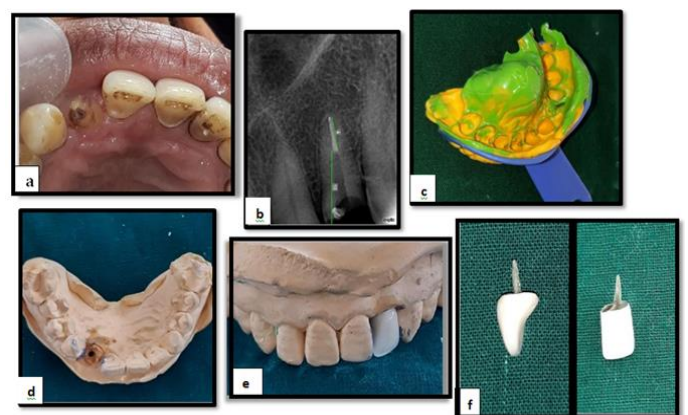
(a) Post space creation done in respect to 22; (b) Radiographic image of post space; (c) maxillary impression taken along with wax pattern with putty; (d)
